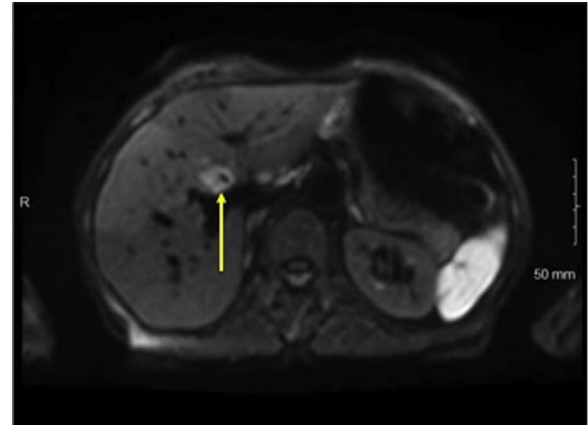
MR abdomen was obtained due to clinical elevation in liver function tests and biliary duct dilatation. T2-weighted and T1-weighted postcontrast MRI images showing T2 hyperintense perihilar lesion with delayed contrast enhancement on T1-weighted image (shown by yellow arrows). MR, magnetic resonance; MRI, magnetic resonance imaging. (Color version of figure is available online.)
